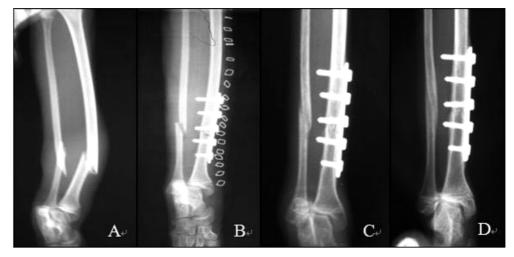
Radiographs prior to surgery (A), after surgery (B), 6 weeks after surgery (C), and 9 weeks after surgery (D). A. Short oblique fractures of the right tibia and fibula. B. Good apposition and alignment of the fractures right after surgery. C. Smooth callus formation visualized on ends of the fracture lines and along the lateral tibia and fibula. D. Bridging callus well formed over cortices of fracture areas.
